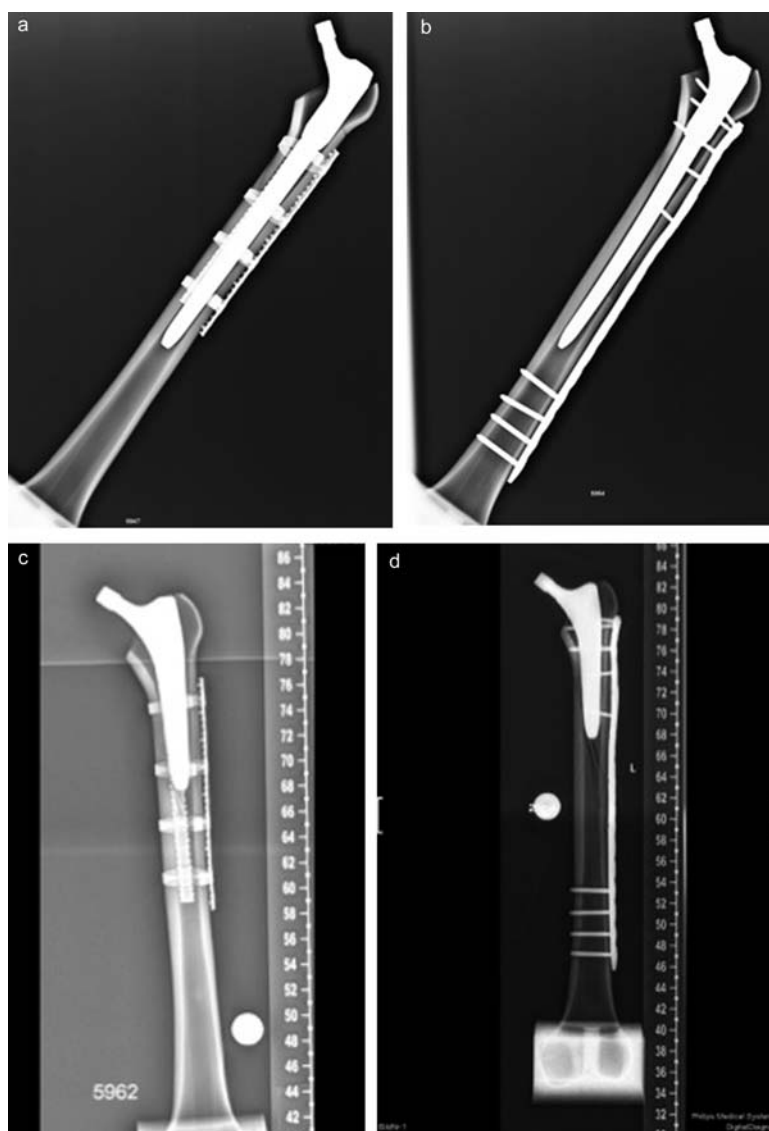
(a) X-ray long revision stem/cerclage. (b) X-ray long revision stem/plate. (c) X-ray short primary stem/cerclage. (d) X-ray short primary stem/plate.
